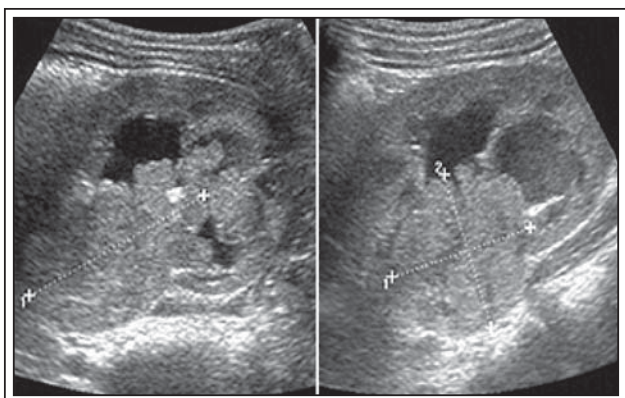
Ultrasound images demonstrating large heterogeneous mass in the collecting system of the left kidney without cortical involvement.
